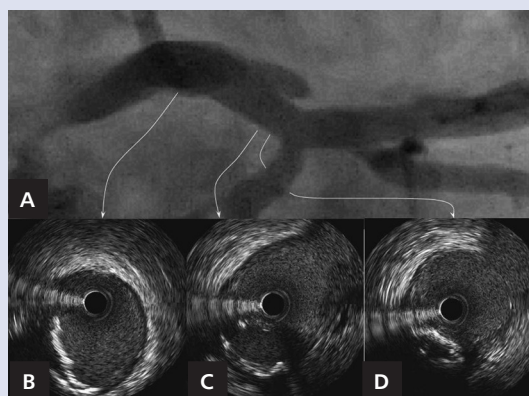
A. Magnification of left main coronary artery; B–D. Corresponding intravascular ultrasound cross-sections with ruptured plaque cavity — seven o'clock (C)
